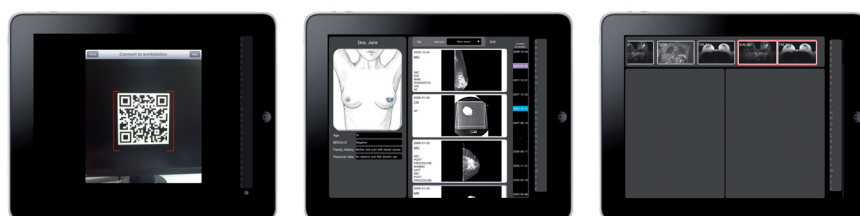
Mobile device screens: Reading the QR code (left), the patient browser interface (middle), and the mobile device user interface during reading (right). MR images are displayed on the primary display (see Fig. 2).
